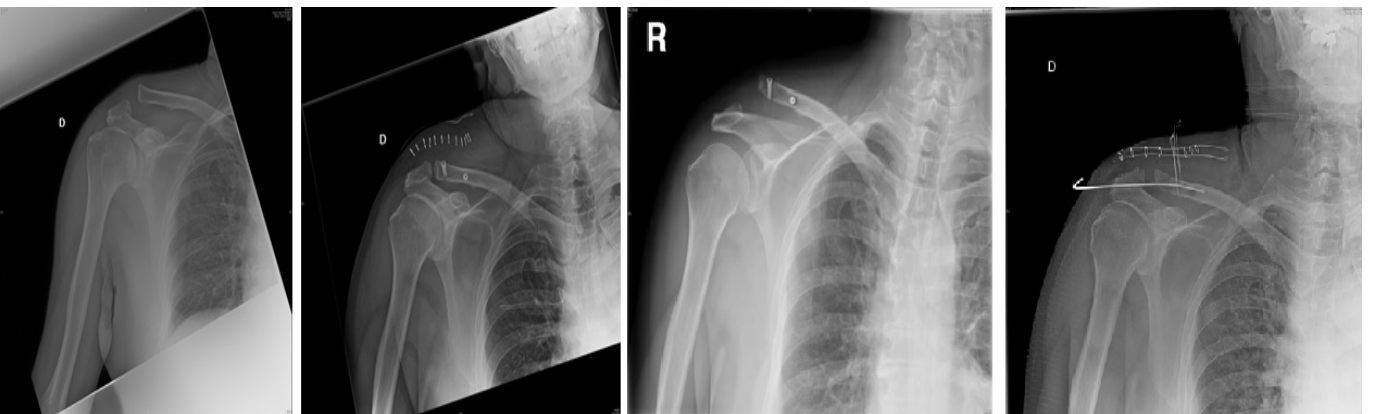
Radiography of a failure of the LARS system in a patient with Rockwood type 3 lesion. A) Initial injury; B) result after the surgery; C) X-ray of the shoulder after severe pain and functional impairment 20 days after surgery; D) surgical revision with K-wires.
